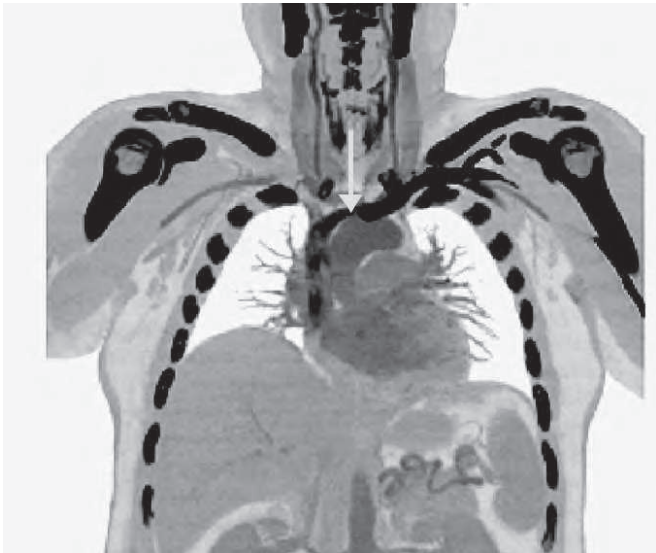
Helical CT scan showing contained aortic hematoma
